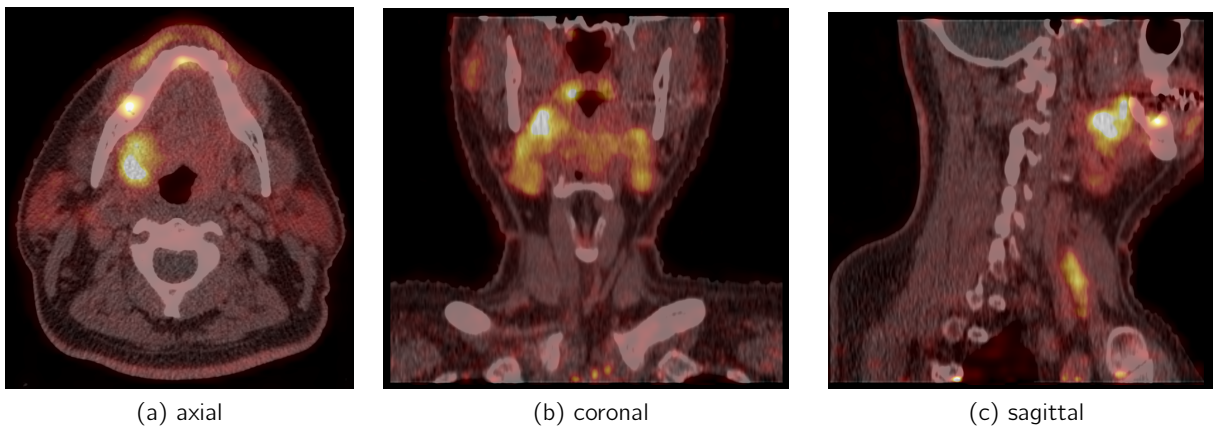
The tumour in the right tonsil loge in three different views on baseline RGD PET with a low-dose CT
